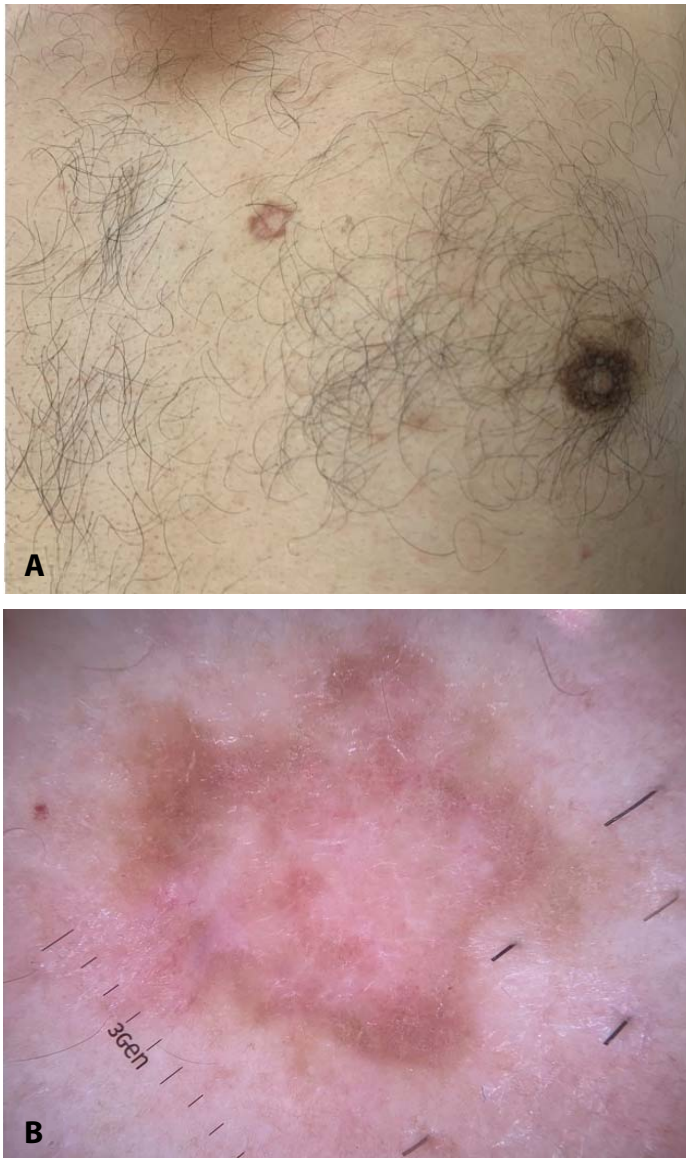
A) Clinical image. A 12mm asymmetric pinkish-brown plaque with a slight scale on the left parasternal area. B) Dermoscopic image. An erythematous background with brown clustered dots and irregular brown structures associated with isolated dotted vessels on the periphery and structureless whitish areas with short shiny white lines on the central zone.
